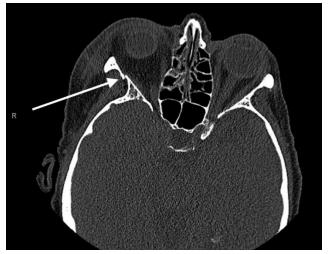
Computed tomography demonstrating right-sided, mildly displaced orbital wall fracture (arrow).
